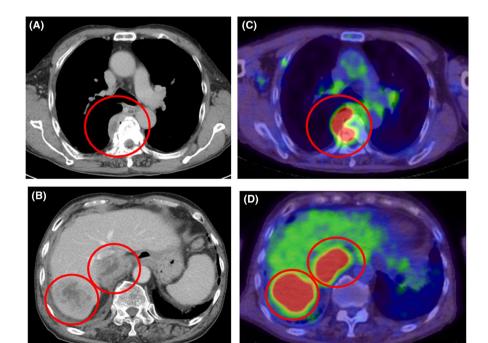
Computed tomography (CT) image. CT shows an osteolytic mass lesion adjacent to the T6-7 vertebrae (A), in addition to the masses in the liver and right adrenal gland (B) (red circles). Fluorodeoxyglucose-positron emission tomography scan showing increased uptake in each lesion (C, D) (red circles)
